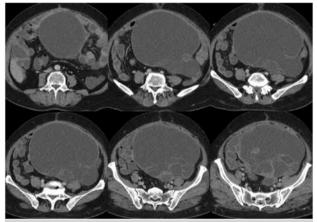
CT sections in which giant ovarian cyst is viewed with the signs of increased intraabdominal pressure, such as edema in the bowel walls and change of place in the intestines
